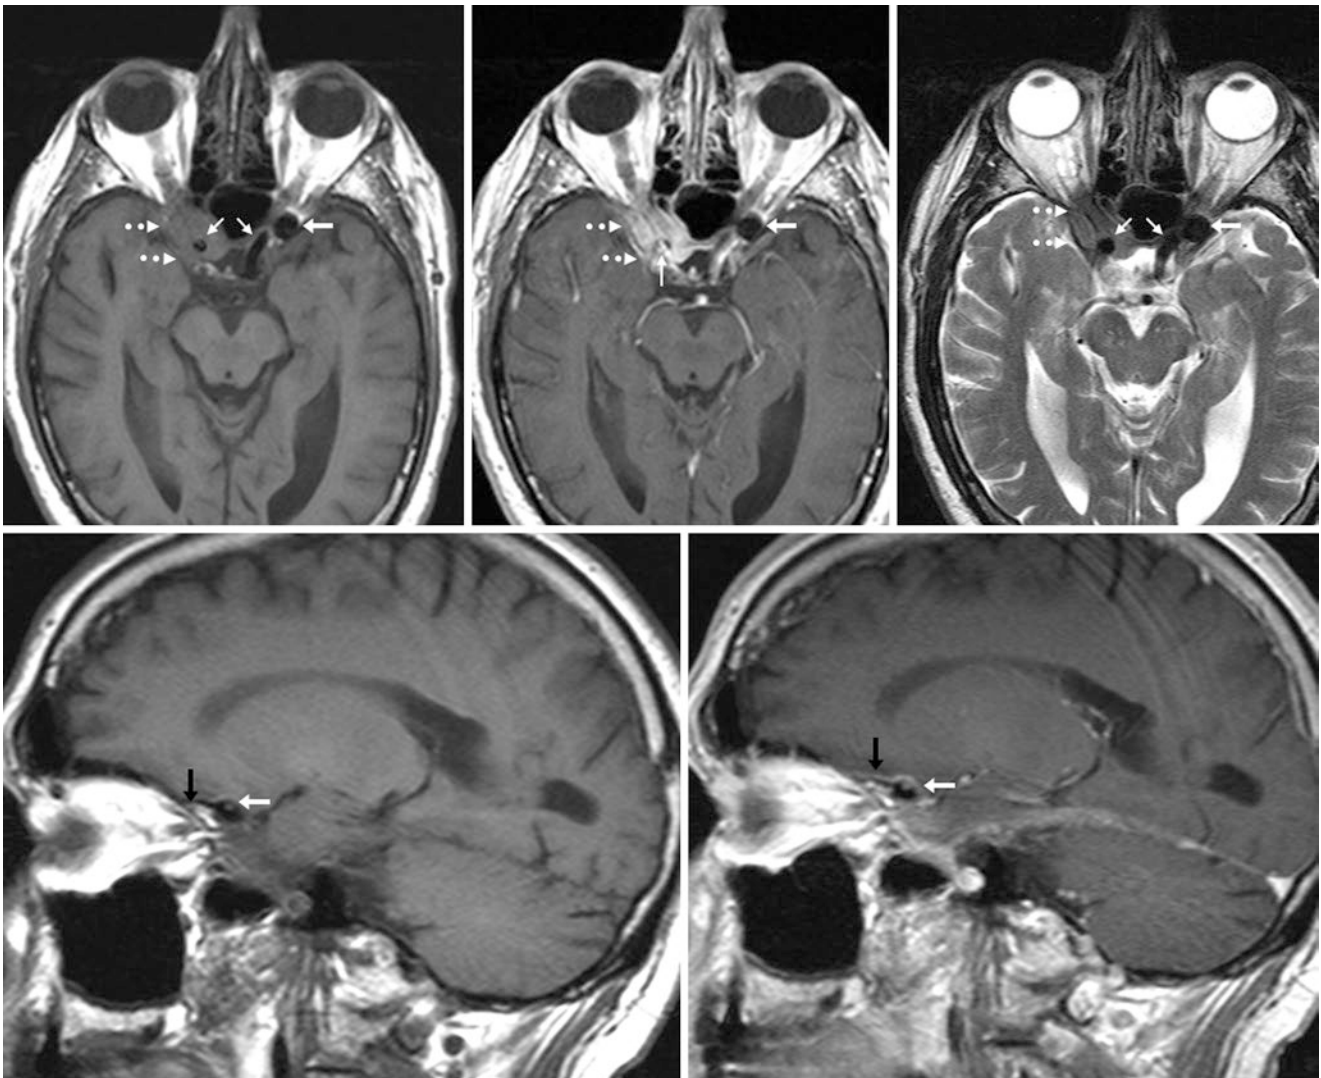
Top row:* An 84 year old with a focus of dark signal (*arrows*) that was initially called a flow void from an ICA aneurysm on axial T1WI MRI pre- (*left*) and postcontrast (*middle*) and T2WI (*right*). *Bottom row:* This was later found to be an aerated anterior clinoid on
